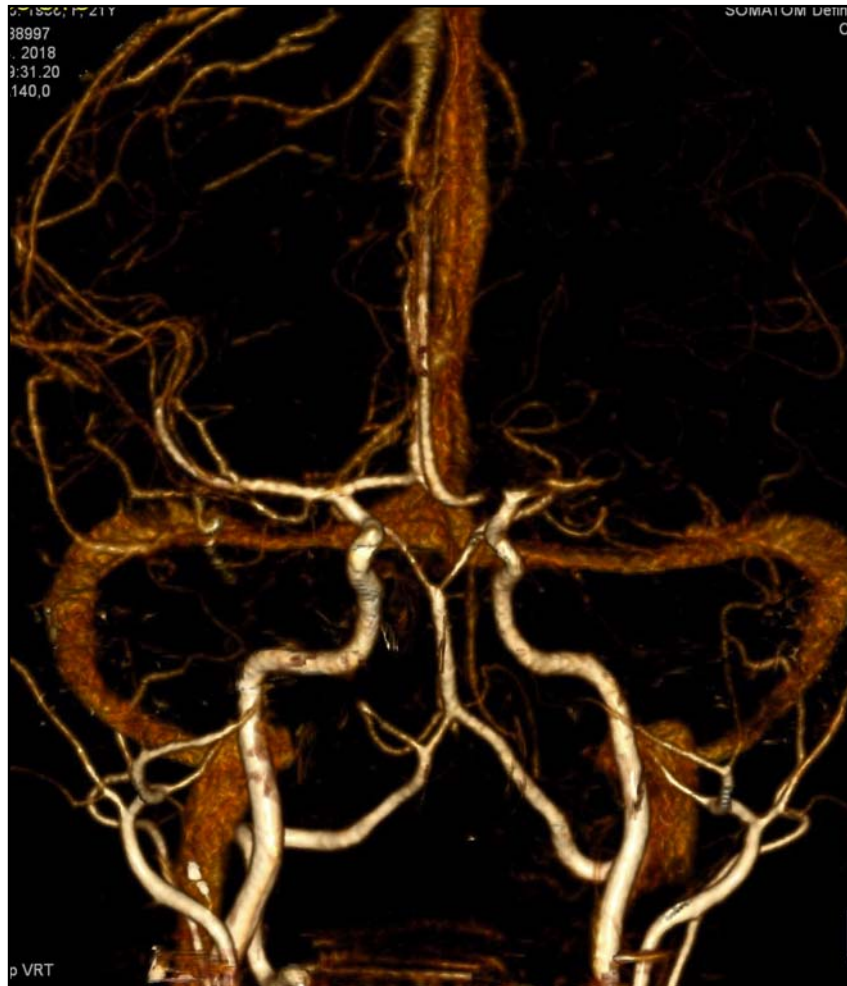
CT angiography revealed occlusion of the left MCA
